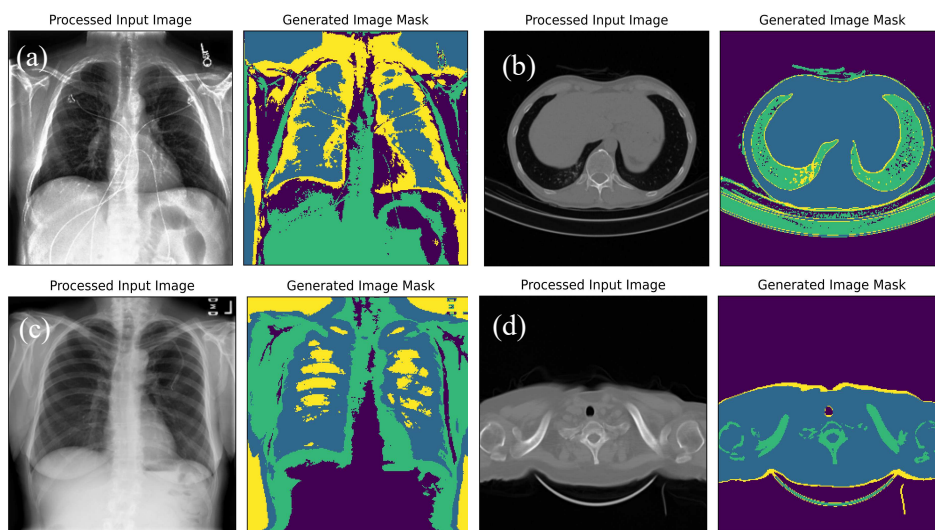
Generated Regions of Interest Masks for input images from the (a) Chexpert dataset, (b) Covidct dataset, (c) Chest-x-ray dataset
